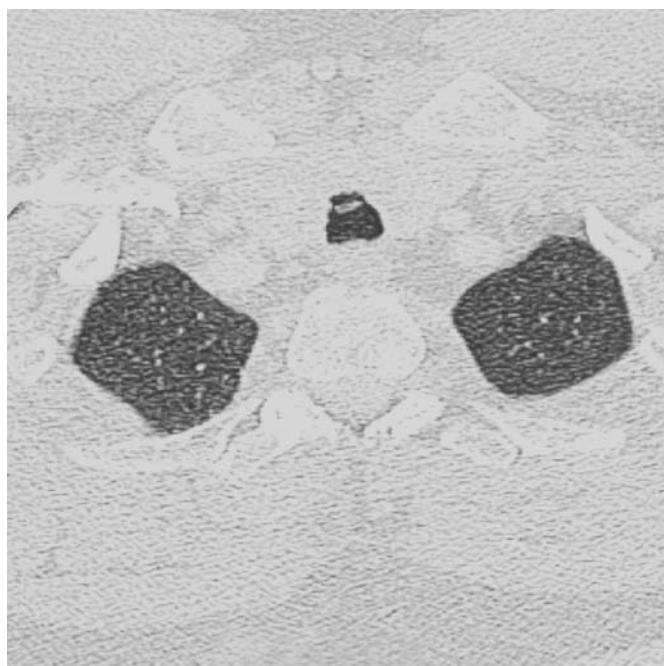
Computed tomography chest showing tracheal foreign body.
